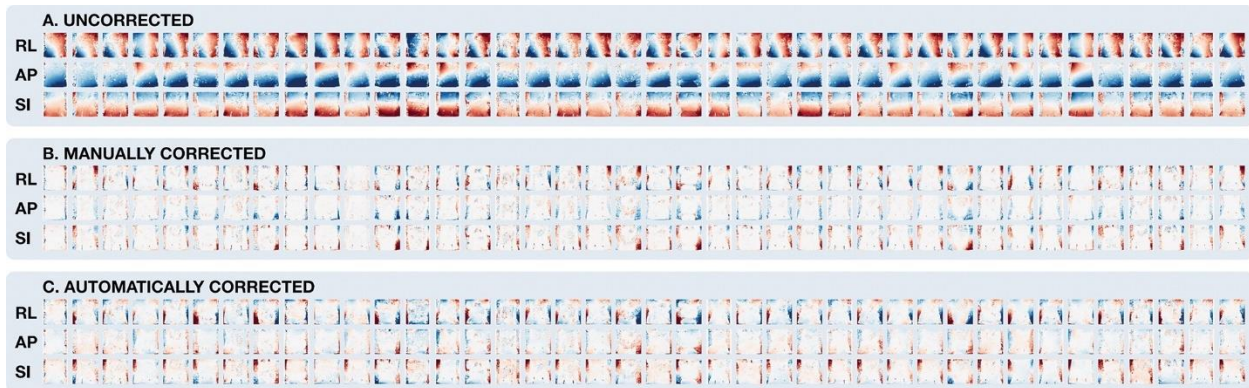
Representative coronal sections of MRI scans from all 40 test cases. With velocity shown on a red-white-blue color scale, manual and automated correction methods show a similar reduction of soft-tissue phase error, seen as primarily white coloring (zero flow). Phase errors for each cardinal direction appear to follow fairly consistent patterns but with slight differences from case to case. AP = anterior to posterior, RL = right to left, SI = superior to inferior.
